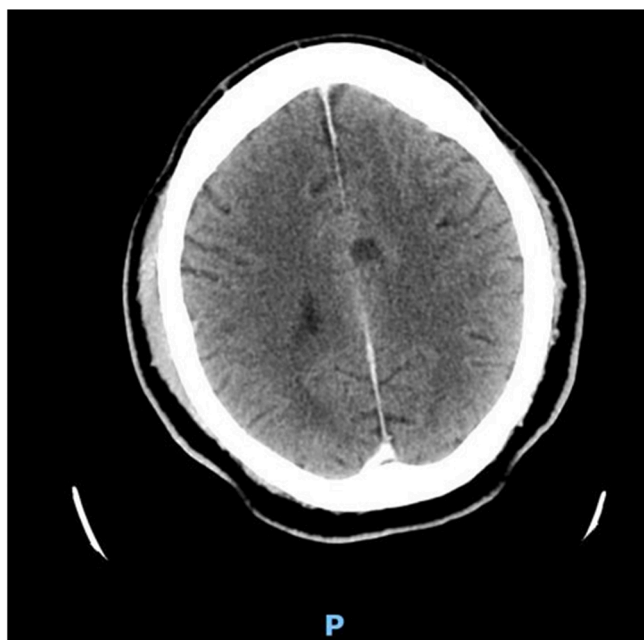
CT head with IV contrast shows a peripherally enhancing lesion in the left parasagittal frontal lobe measuring 2 × 2×2 cm.
